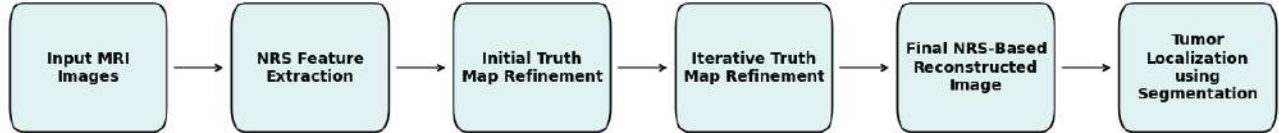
NRS-Based MRI Reconstruction and Tumor Localization
